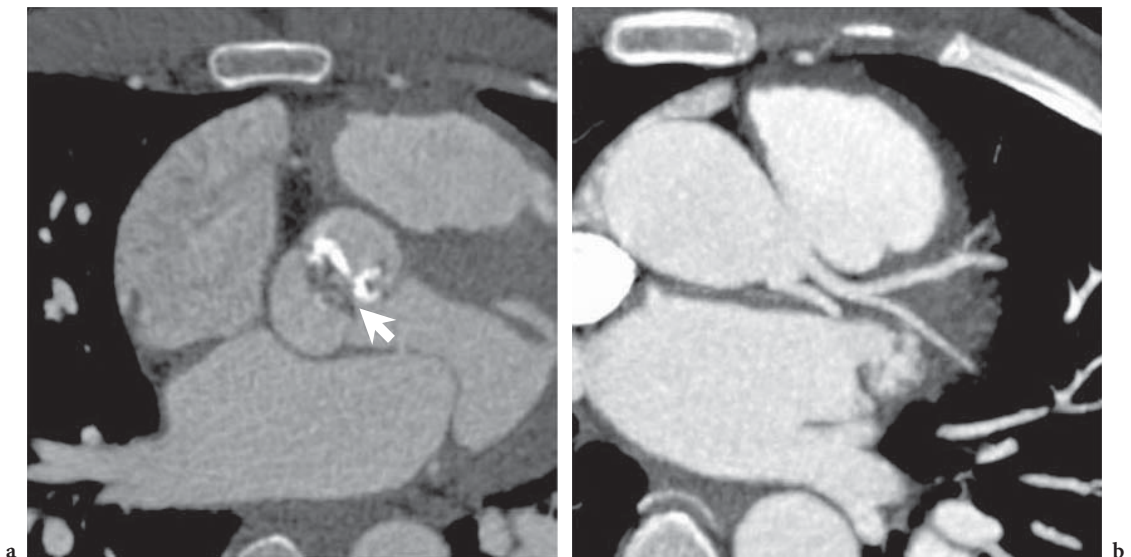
Patient investigated with 64-slice CT. Severe calcification and vegetation of a bicuspid aortic valve (a, *arrow*). This patient had a split left coronary artery with separate origins of the left anterior descending and the circumflex coronary artery (b)
